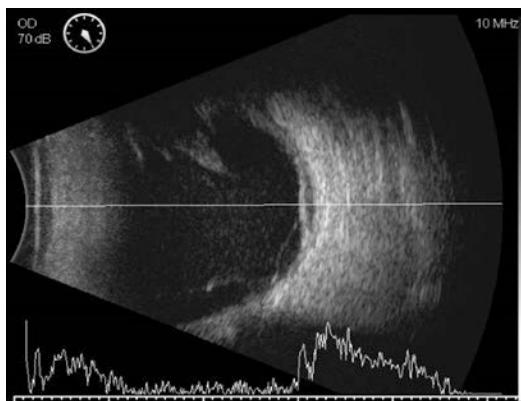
B-ultrasound examination in the right eye. The vitreous is opacity and retinal detachment is suspected
